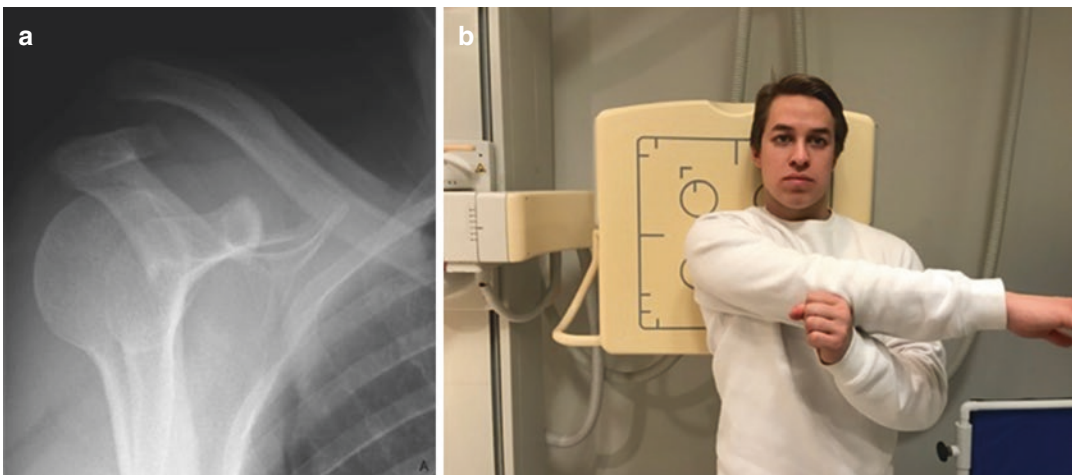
Cross-body adduction view, also known as the Alexander view or the Basamania view. (a) Radiograph image, (b) patient positioning for obtaining this view
